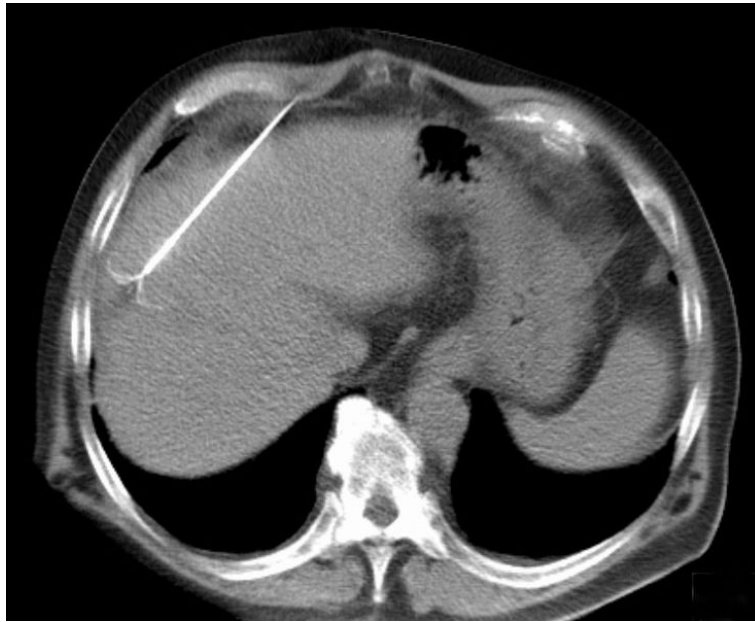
A CT slice showing radiofrequency ablation probe in the liver. *Image from Wikipedia*⁵
